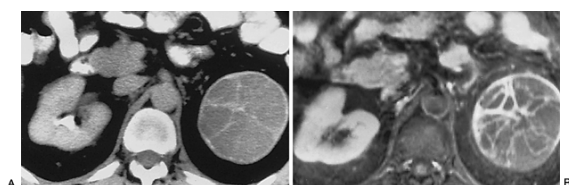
8. The value of fat-suppressed T₁-weighted enhanced magnetic resonance imaging (MRI) for detecting mural enhancement. A: Contrast-enhanced computed tomography (CT) scan demonstrates a large cystic mass in the left kidney. It is not evident how much enhancement there is in the wall of the mass. B: Fat-suppressed T₁-weighted image after gadolinium enhancement demonstrates markedly enhanced irregular walls of the cystic mass, suggesting a malignancy. This lesion proved to be a cystic renal cell carcinoma.
